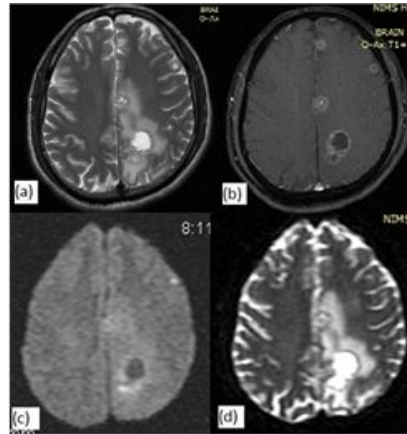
A 50 year old female with multiple cerebral metastasis from carcinoma of lung. Fig (a) Multiple heterogeneous lesions surrounded by disproportionate perilesional edema on T2 weighted image; Fig (b) Multiple irregular nodular ring enhancing lesions on post contrast T1; Fig (c) DWI depicting non restriction s/o facilitated diffusion in the centre with elevated signal in the periphery; Fig (d) shows ADC map. The ADC values at the core, periphery and peritumoral region in this case were $235 \times 10^{-5} \text{ mm}^2/\text{s}$, $113 \times 10^{-5} \text{ mm}^2/\text{s}$ and $150 \times 10^{-5} \text{ mm}^2/\text{s}$, respectively.
